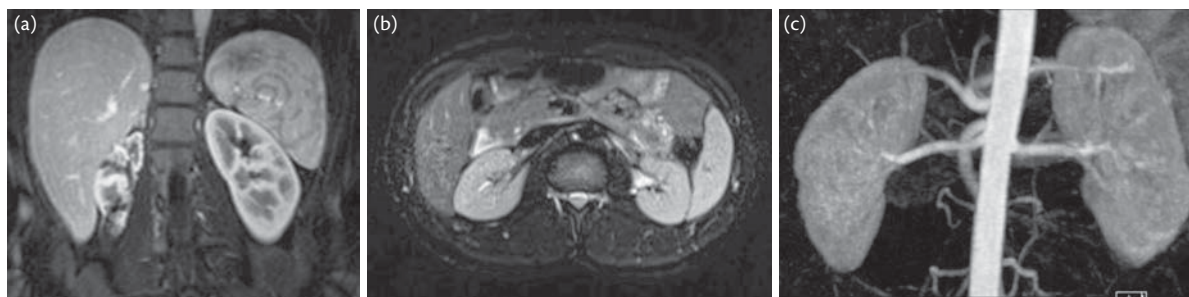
Normal magnetic resonance image (MRI) of the kidneys: coronal gadolinium-enhanced magnetic resonance image of the kidneys, scarred atrophic right kidney and normal left kidney (a), axial pyelographic phase image of kidneys (b), coronal maximum intensity projection of an magnetic resonance angiogram (MRA) (c).
